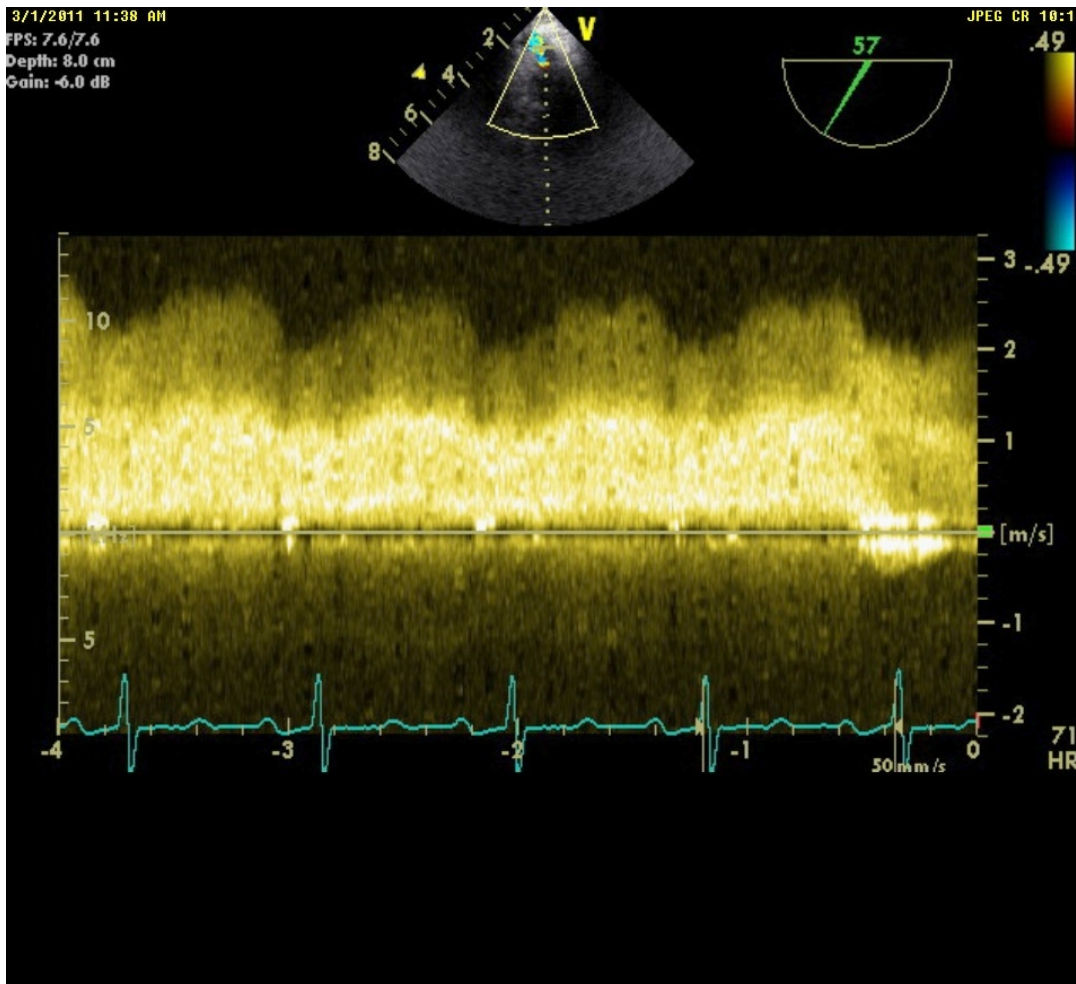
Continuous wave Doppler showed a high velocity continuous flow into the left atrium with relatively little variation in peak velocities throughout the cardiac cycle. The peak velocity was about 2.5m/sec corresponding to a peak gradient of 25mmHg. The mean gradient was measured at about 20mmHg
